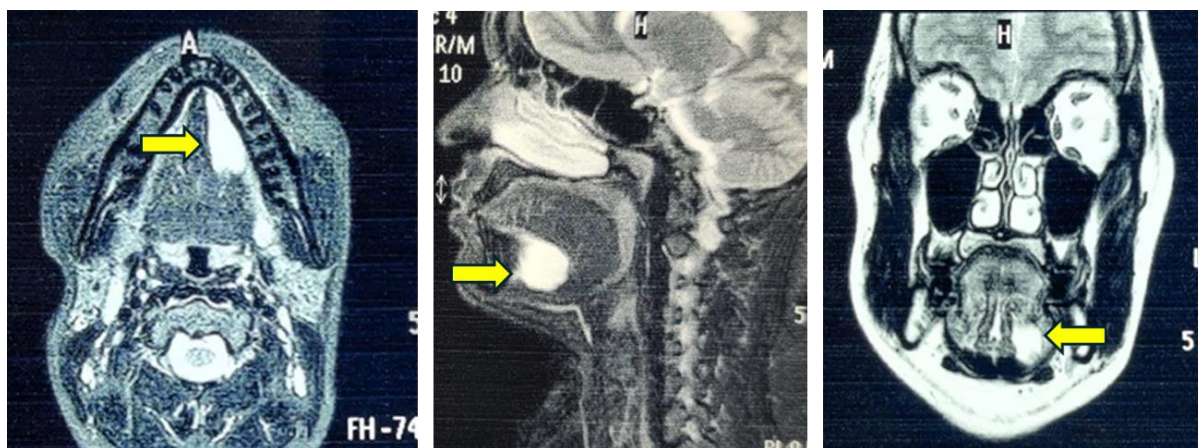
Contrast-enhanced magnetic resonance imaging showed the lesion appeared as a well-defined, round cystic structure with homogeneous high signal intensity on T2-weighted images, consistent with fluid content typical of a mucous retention cyst (ranula). Source: Authors, 2024.
